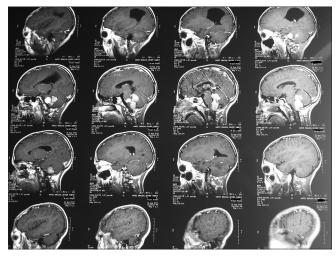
Saggital magnetic resonance imaging with contrast: Meningioma in $4^{\rm th}$ ventricle
